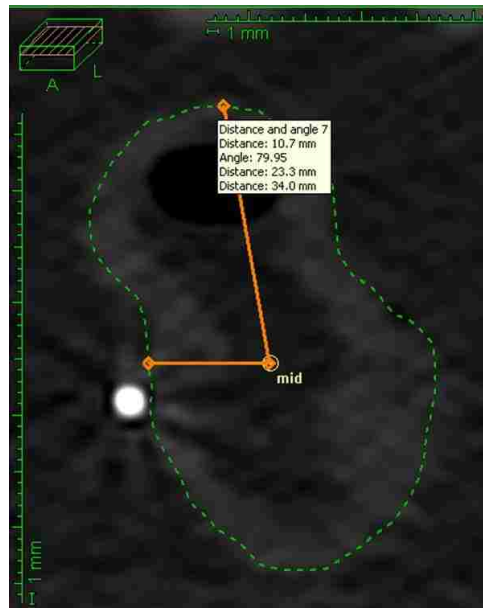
Example of use of Oncentra’s “Distance and Angle” tool on an axial CT slice of a surrogate rectum structure.
